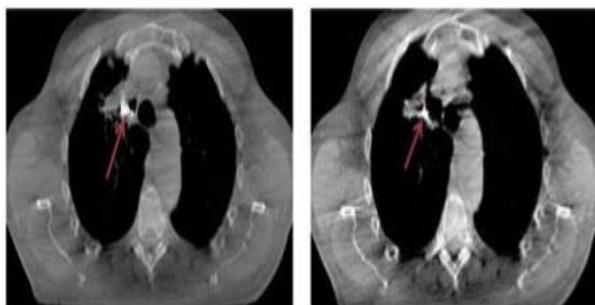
CBCT images of patient 1 at fraction 2 (left) and fraction 32 (right). Marker indicated by arrow.
